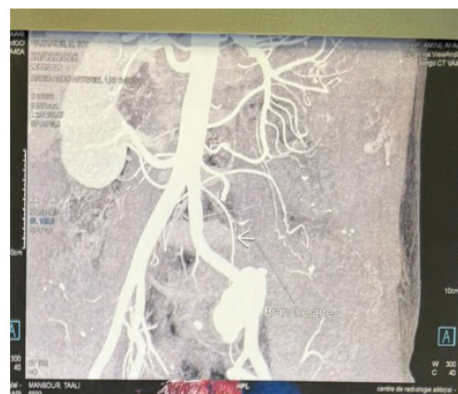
CT angiographic reconstruction showing the aberrant vascular anatomy of the left pelvic ectopic kidney.
